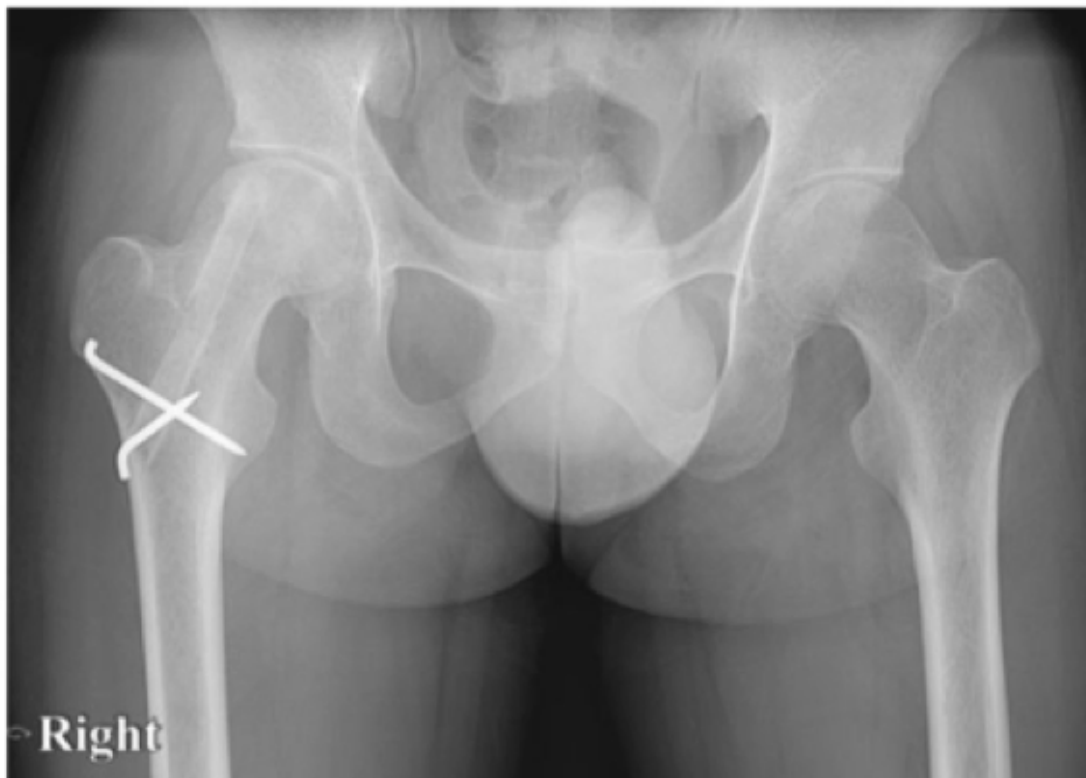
A post-operative radiograph demonstrating a restored femoral head and a fibular allograft. The allograft is secured within the core by two Steinmann pins that cross both cortices of the femur and the lateral femoral cortex (Yoon et al., 2012, p. 947).
